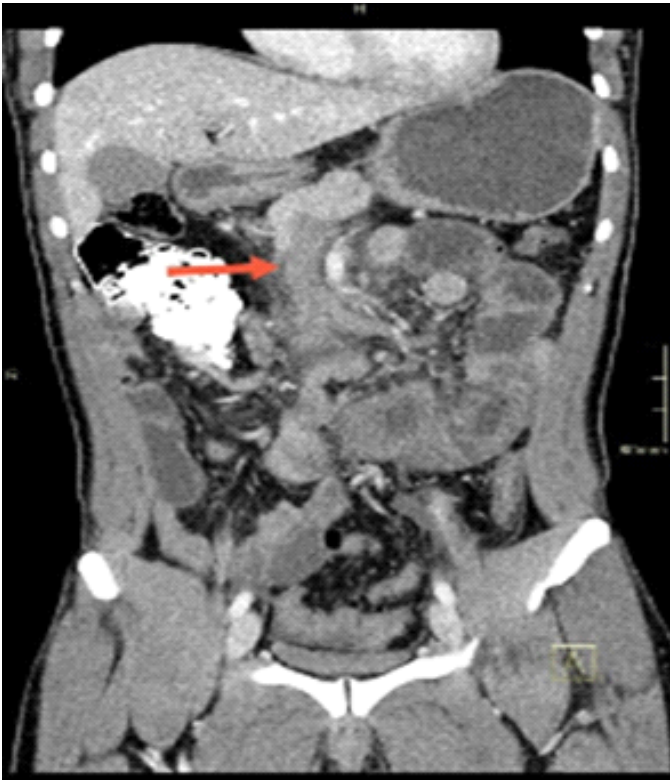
CT image showing superior mesenteric vein thrombosis
